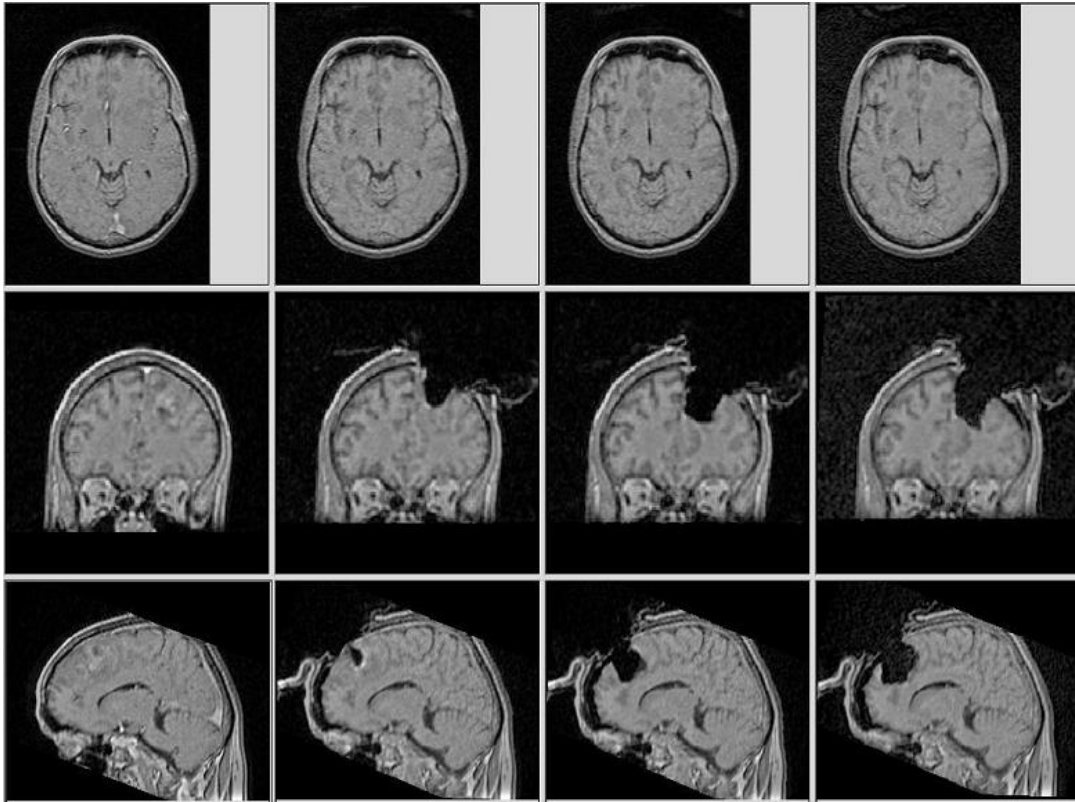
Intra-operative MRI scans acquired before opening the skull (left) and at certain timepoints during the intervention. The brain deformation is best observed on the sagittal scans (bottom row).
